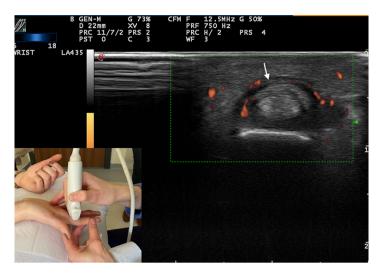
Axial scan of the increased thickness of A2 pulley and intra-pulley power doppler signals. White arrow: A2 pulley.
